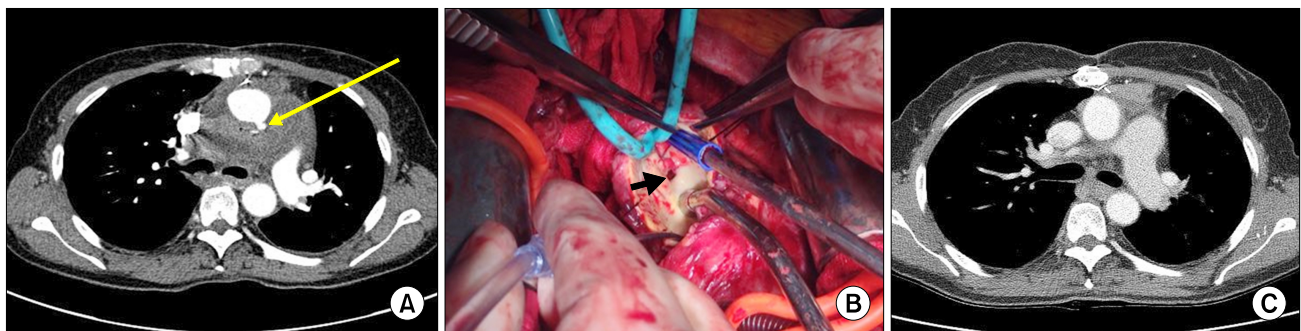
(A) A CT image two months after the second operation shows a recurrent pseudoaneurysmal sac at the repaired site (arrow). (B) A photograph taken during the last operation shows an opening of the pseudoaneurysmal sac (arrow). (C) A postoperative CT image six months after the last operation shows the repaired aorta. CT, computed tomography.
